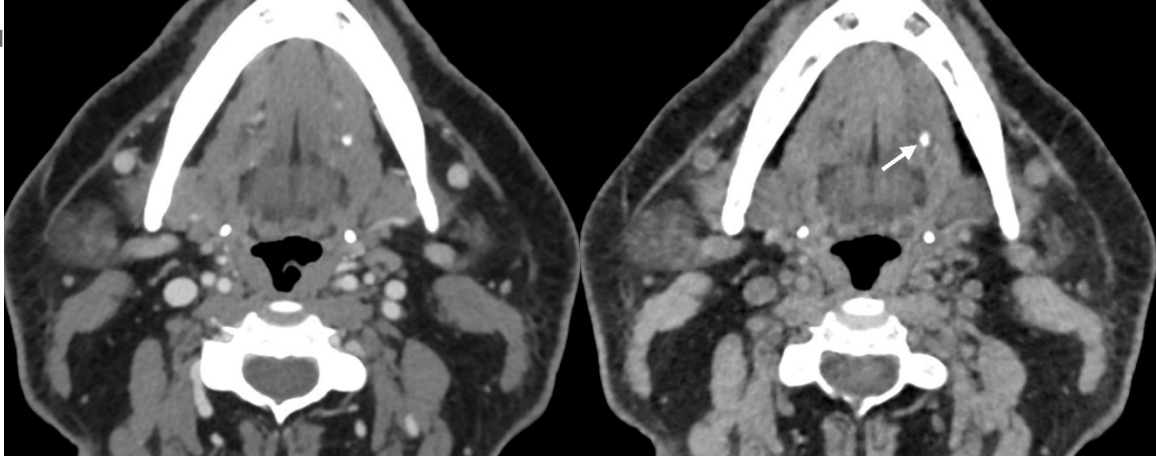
Virtual monochromatic imaging (B) derived from contrast-enhanced dual-energy CT (A) more easily depicts a salivary stone (arrow) of the left submandibular duct.
